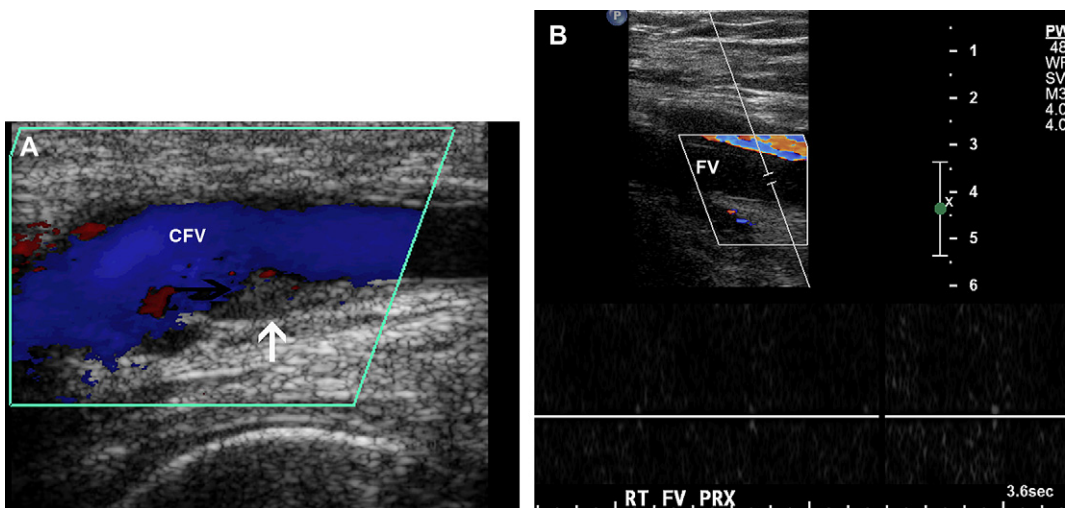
(A) Color Doppler filling defect in the common femoral vein (*CFV*) caused by mural thrombus (*arrow*). (B) Absence of color flow and spectral waveform in completely thrombosed right femoral vein. Note color flow in adjacent femoral artery.
